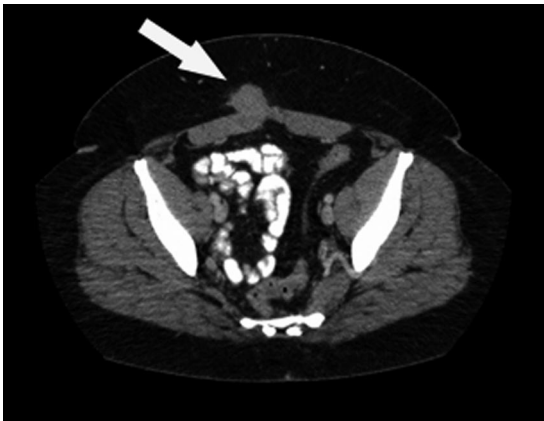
CT of the abdomen reveals a mass suggestive of a ventral hernia.
